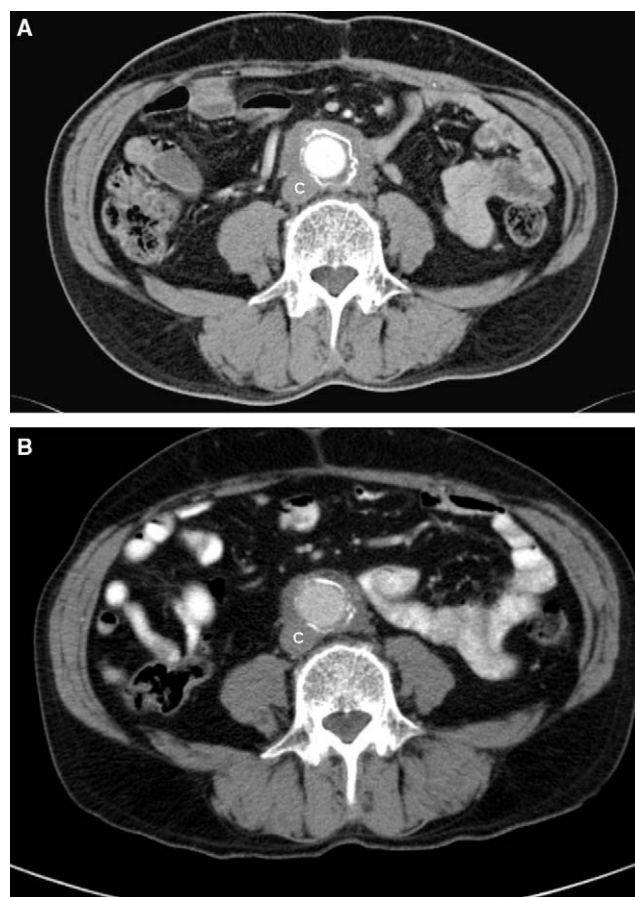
(A) Eleven-month postoperative CT scan in a 64-year-old man shows the aortic bypass graft and a peri-aneurysmal soft tissue mass with limited involvement of inferior caval vein (C). (B) Note that the posterior aortic wall is spared. A follow-up CT scan after 4 months of tamoxifen treatment shows regression of the peri-aortic mass.
